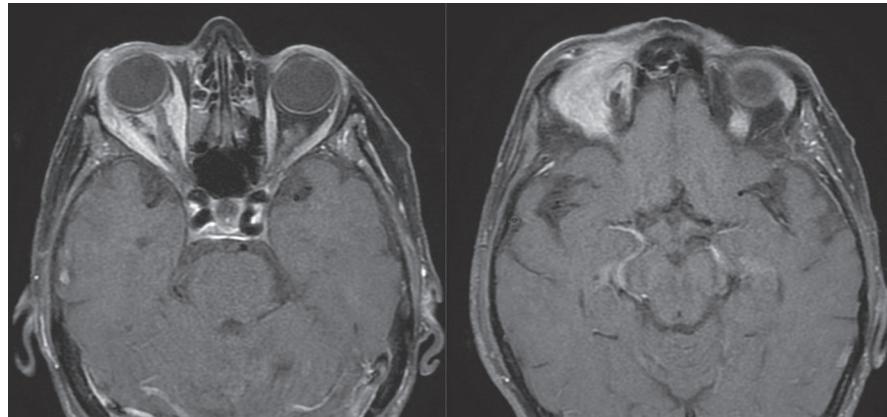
Left, MRI brain with contrast, axial T1 image with fat suppression depicting extraocular muscle enlargement. Right, MRI brain with contrast, axial T1 image of lacrimal gland, and extraocular muscle encased with infiltrative process.
